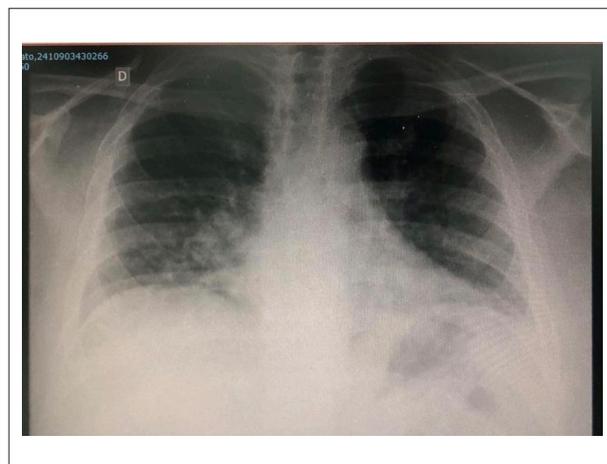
Chest radiography at first visit.
